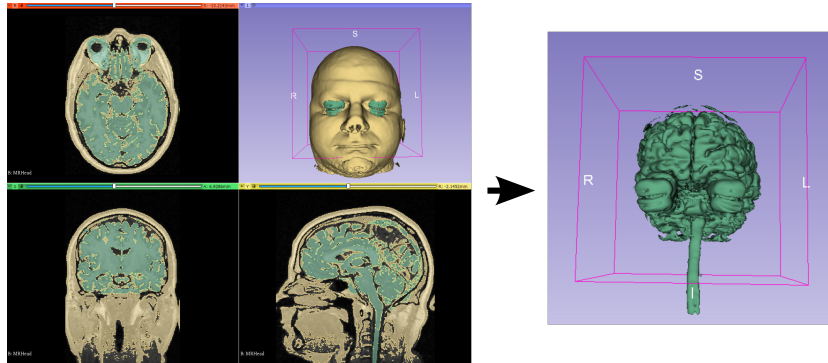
Example of an MRI scan segmented using the software 3D Slicer. Medical imaging was used with the consent of the patient who preferred to remain anonymous.
